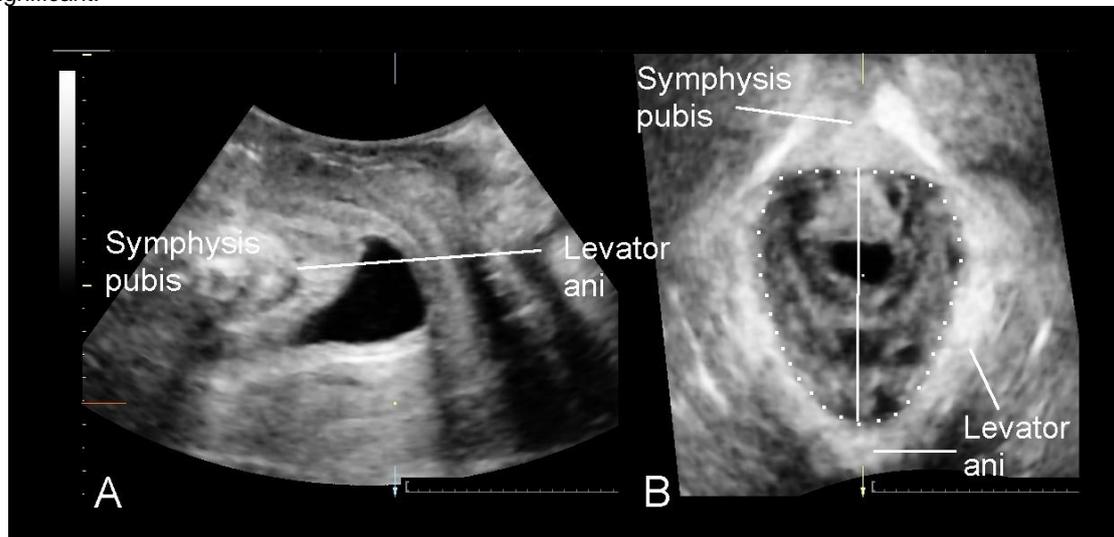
Determination of hiatal dimensions by translabial ultrasound. The left figure (A) shows a midsagittal view on maximal Valsalva. The white line defines the plane of minimal hiatal dimensions which is shown in the axial plane image on the right (B). The vertical white line on the right is the midsagittal hiatal diameter, the dotted line demonstrates measurement of the hiatal area on Valsalva.
